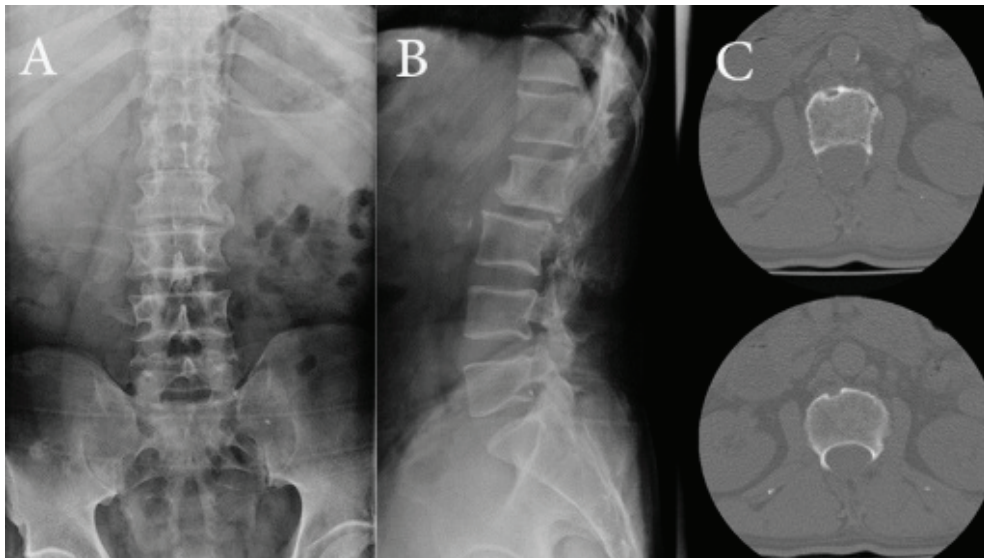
Plain radiographs of the lumbar spine. Anteroposterior (A) and lateral (B) views show instability in L2 and L3. Axial computed tomography (CT) image (C) reveals evidence of agenesis of the pars interarticularis, spinous processes, lamina, transverse processes and facets at L2 and partial L3.
